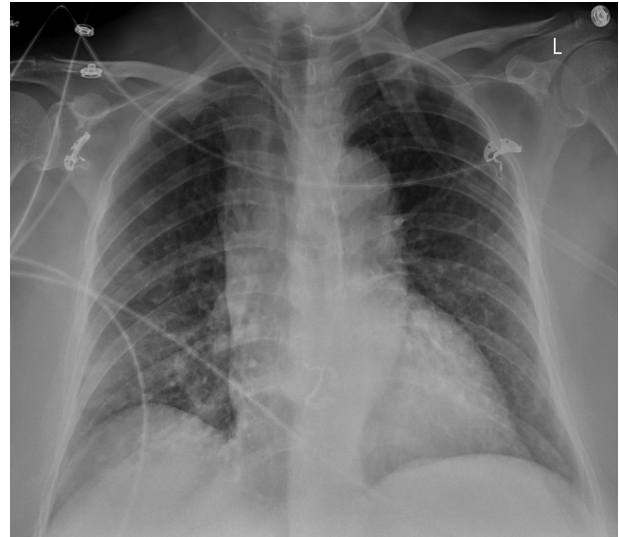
AP portable chest X-ray demonstrating bilateral and diffusely distributed nodular opacities seen in DPM
